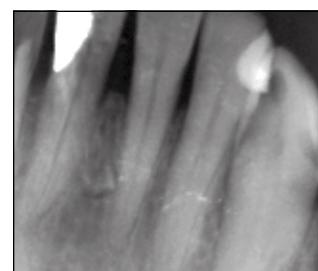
A preoperative radiograph of tooth No. 25.
